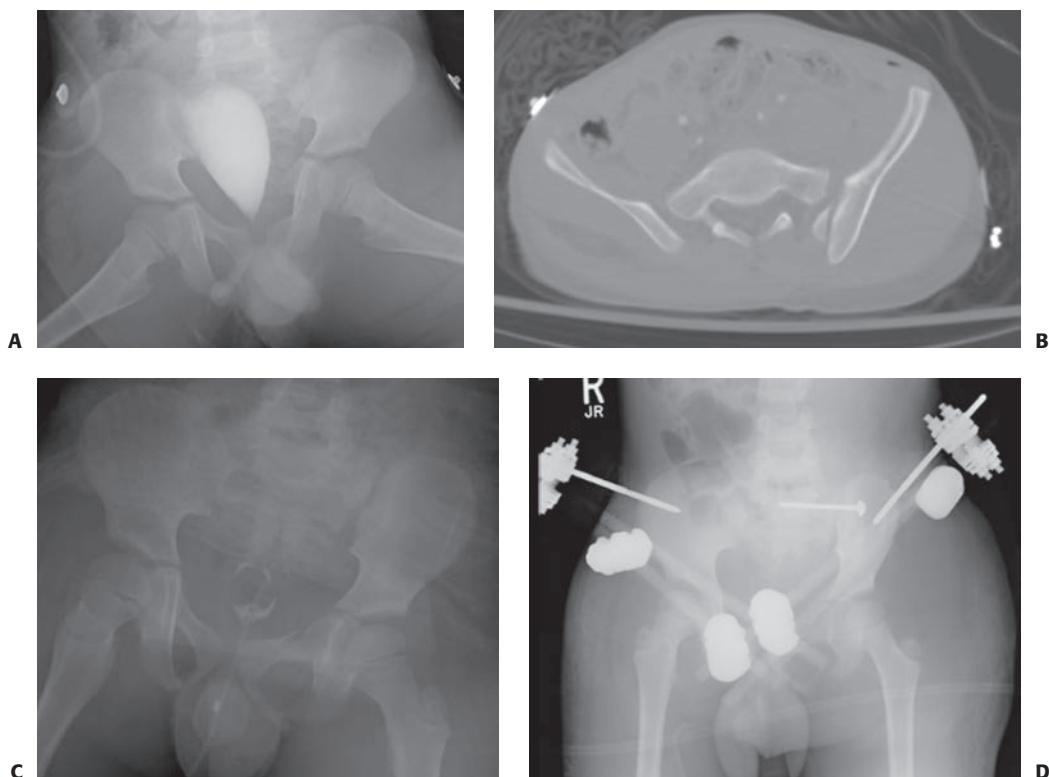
A 6-year-old boy who was struck by a school bus. He had a pneumothorax and a pelvic fracture. AP pelvis (A) and initial CT scan (B) show an unstable type IV fracture with vertical displacement of the hemipelvis. He was placed in traction during resuscitation (C) with realignment of the fracture. After stabilization 6 days after injury, he underwent closed reduction, SI screw fixation, and application of an external fixator. Post-op radiograph (D) of the pelvis and CT scan (E) show near-anatomic reduction.
